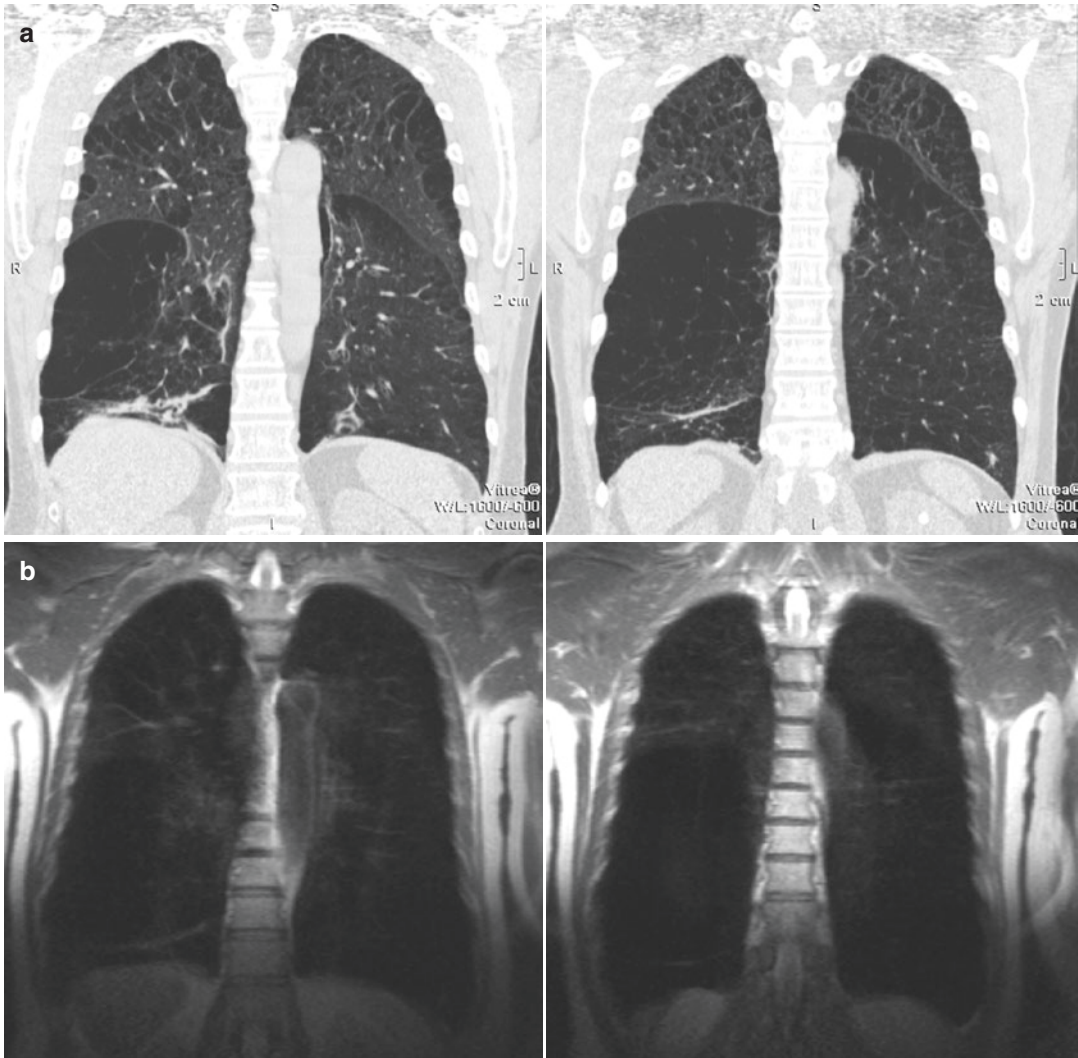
Coronal CT reformats (a) and corresponding coronal T2-weighted (HASTE) images (b): severe emphysema with predominance of the right lower lobe on CT
